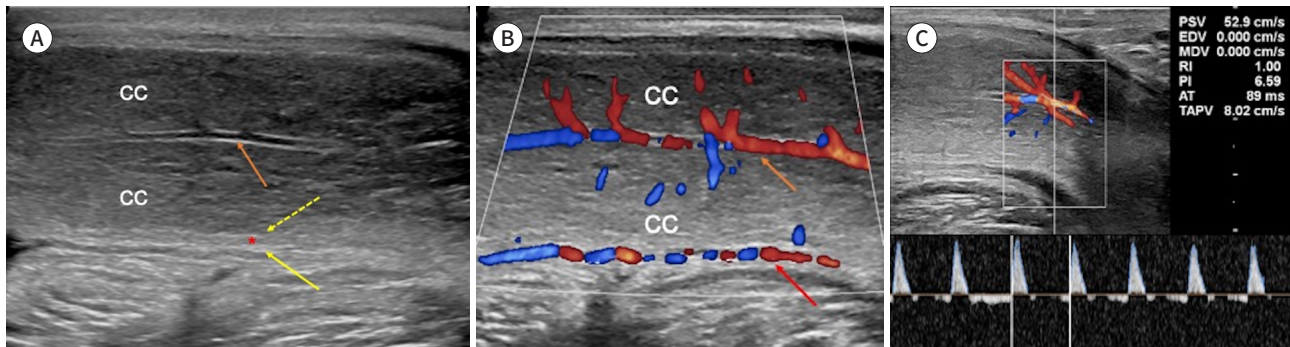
Longitudinal US and Doppler sonographic penile anatomy.
